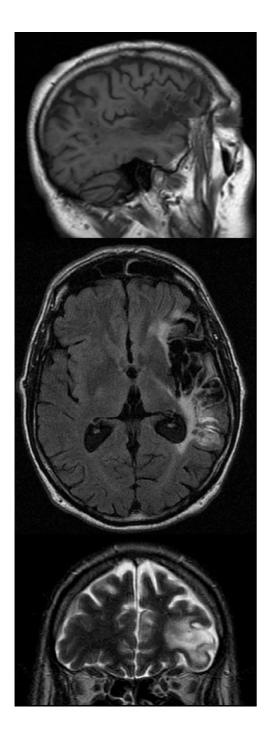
WBA's MRI scan result showing his right lesion.
